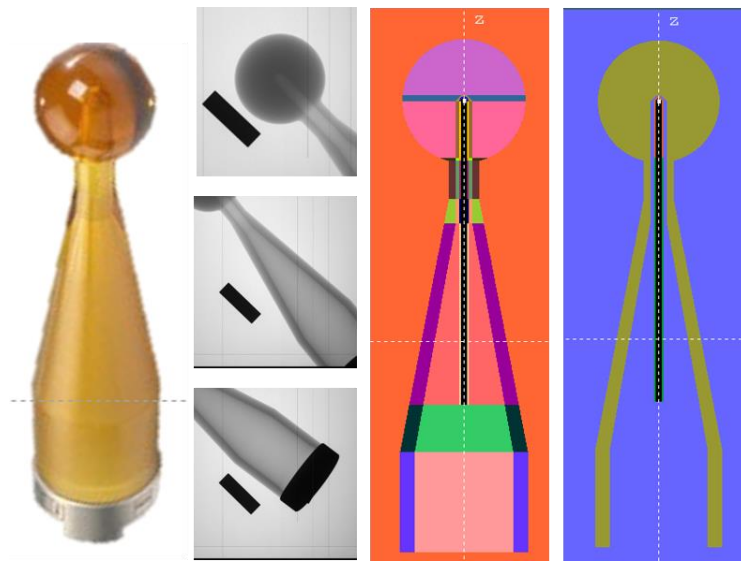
(from left to right) 4 cm spherical applicator of the IB-XRS; three radiography images of the 4 cm applicator with a scaling piece used for applicator dimensions calculations; developed geometry of the entire applicator (with metallic ring discarded) together with the XRS probe, in bodies view mode & materials view mode, both along the axial plane.
